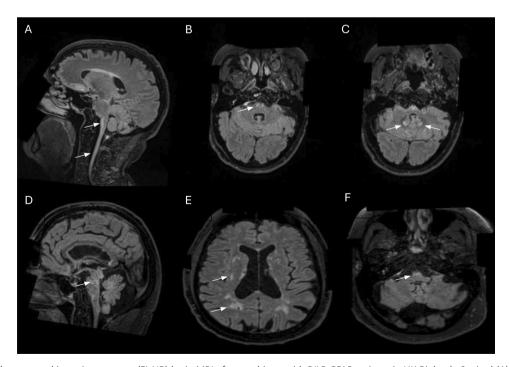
T2 Fluid-attenuated inversion recovery (FLAIR) brain MRI of two subjects with P/LP GFAP variants in UK Biobank. Sagittal (A) and axial (B, C) slices of a man in his 50s, carrying p.Asp128Asn variant previously reported as pathogenic. This subject self-reported as having a 'demyelinating disease (not multiple sclerosis)' as well as having 'urological problems'. There is atrophy of the medulla and cervical cord (arrows in A), with associated hyperintensity (arrow in B). There are also bilateral high signal intensities in both cerebellar dentate nuclei (arrows in C). The supratentorial white matter is spared. Sagittal (D,E) and axial (F) slices of another man in his 50s, carrying a p.Arg376Gln variant previously described as likely pathogenic. There are multifocal supratentorial and pontine white matter abnormalities (arrows in D, (E), with a microvascular appearance as well as changes in signal intensity in the medulla oblongata (arrow in F). There is less atrophy than seen in the first patient. GFAP, glial fibrillar acidic protein; P/LP, pathogenic and likely pathogenic variants.
